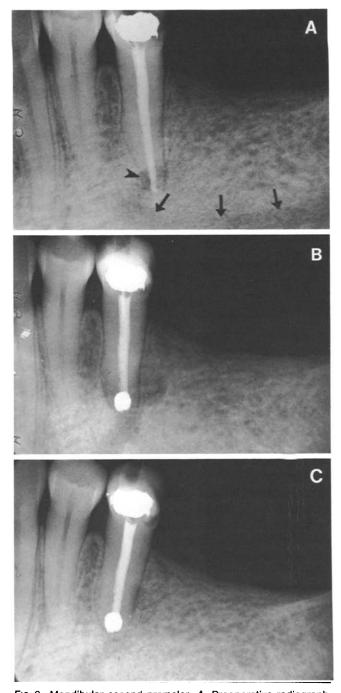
Mandibular second premolar. *A*, Preoperative radiograph. After completion of root canal treatment, the patient continued to have discomfort. Note the overfilled gutta point closely associated with the mental foramen (*arrowhead*) and also the communication between mental foramen and mandibular canal (*arrows*). *B*, Postoperative radiograph. During periapical surgery, the mental foramen and its neurovascular content were carefully exposed. The root apex was resected and retrograde amalgam placed. *C*, Follow-up radiograph. Six months after periapical surgery, the tooth was asymptomatic and there was sign of bony healing. The patient did not experience any symptoms of paresthesia.
